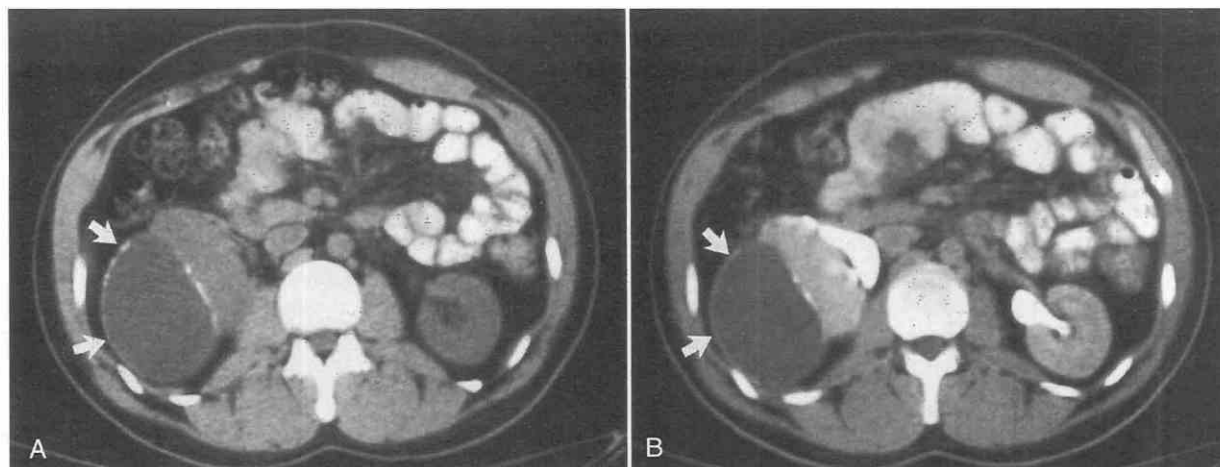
Chronic calcified subcapsular hematoma in a hypertensive man. The low-density (17 HU) posterolateral mass with peripheral calcification (*arrows*) causes anteromedial displacement of the right kidney as seen on unenhanced (A) and contrast-enhanced (B) CT scans.
